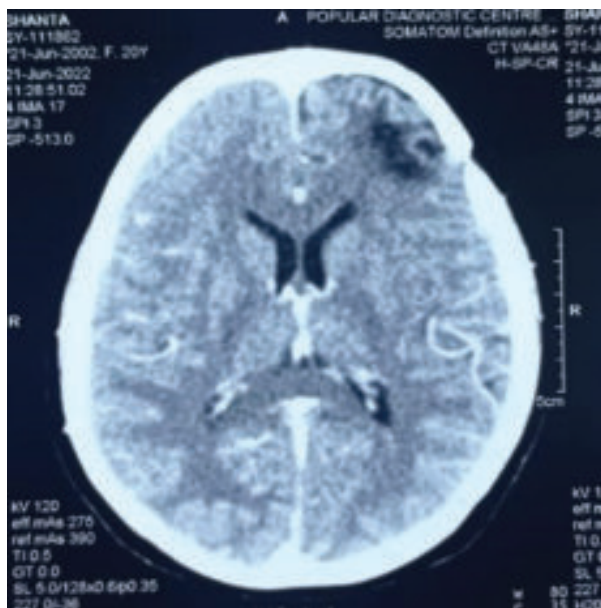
Postoperative contrast CT scan axial shows no residual lesion, mild encephalomalacic change at operated site.
